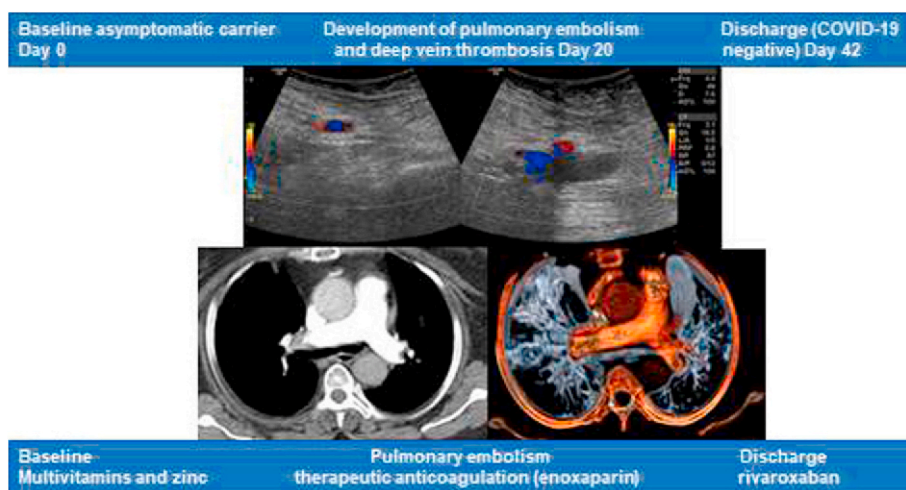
Clinical course of our asymptomatic COVID-19 patient (case 1) from baseline to the development of deep vein thrombosis of the right external iliac and femoral veins as depicted by duplex ultrasound; and pulmonary embolism as depicted by contrast chest computed tomography, which revealed filling defects of segmental and lower lobular branches of the right pulmonary artery. Finally the patient was discharged on rivaroxaban therapy.
